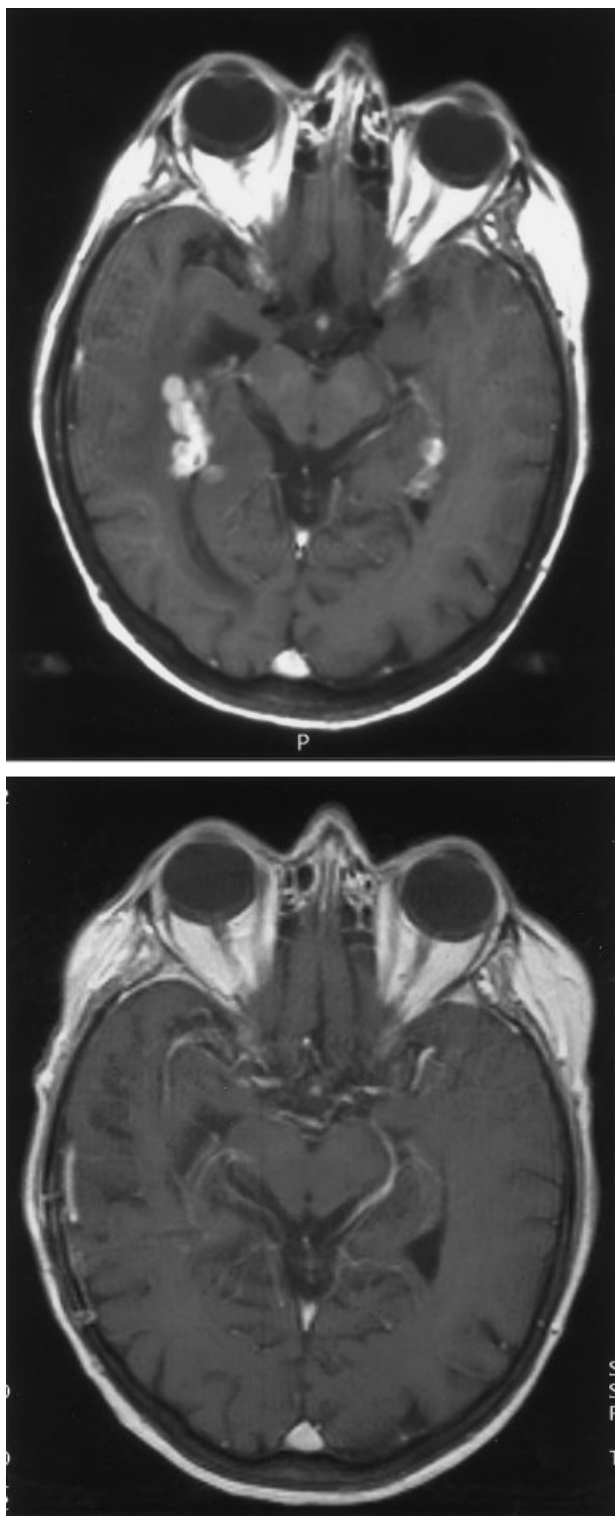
(A) Axial view of a gadolinium-enhanced magnetic resonance image of Patient 5 at the time of recurrence of systemic diffuse large B-cell non-Hodgkin lymphoma in the central nervous system only. This patient had a calculated creatinine clearance of 28 mg/L per minute as a result of renal insufficiency caused by chronic urinary tract infection following radical cystectomy with ileal conduit. (B) After 2 cycles of rituximab and temozolomide, the patient achieved a complete response, which has been maintained for > 12 months.
